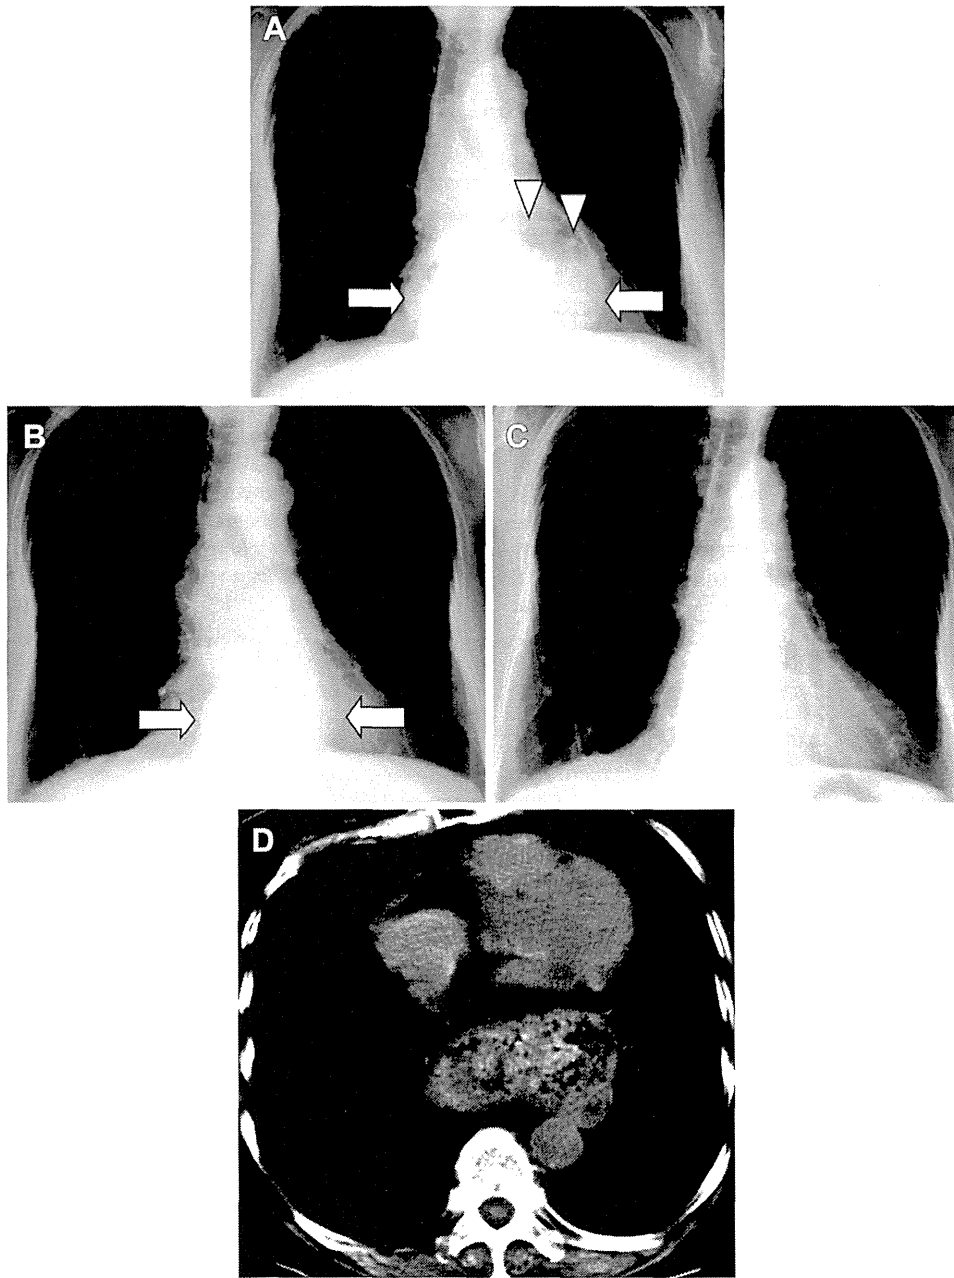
Chest roentgenography reveals (A) a large mass overlapping with the heart (arrows), which includes the air–fluid level (arrowheads), with a pulmonary scar in the right lower field. Retrospective analyses using the chest roentgenograms show that (B) the mass was found on the film obtained 2 years previously (arrows), and that (C) it was not detected on the film 4 years ago. (D) Chest computed tomography indicates a large hiatus hernia with intrathoracic stomach located behind the left atrium.
